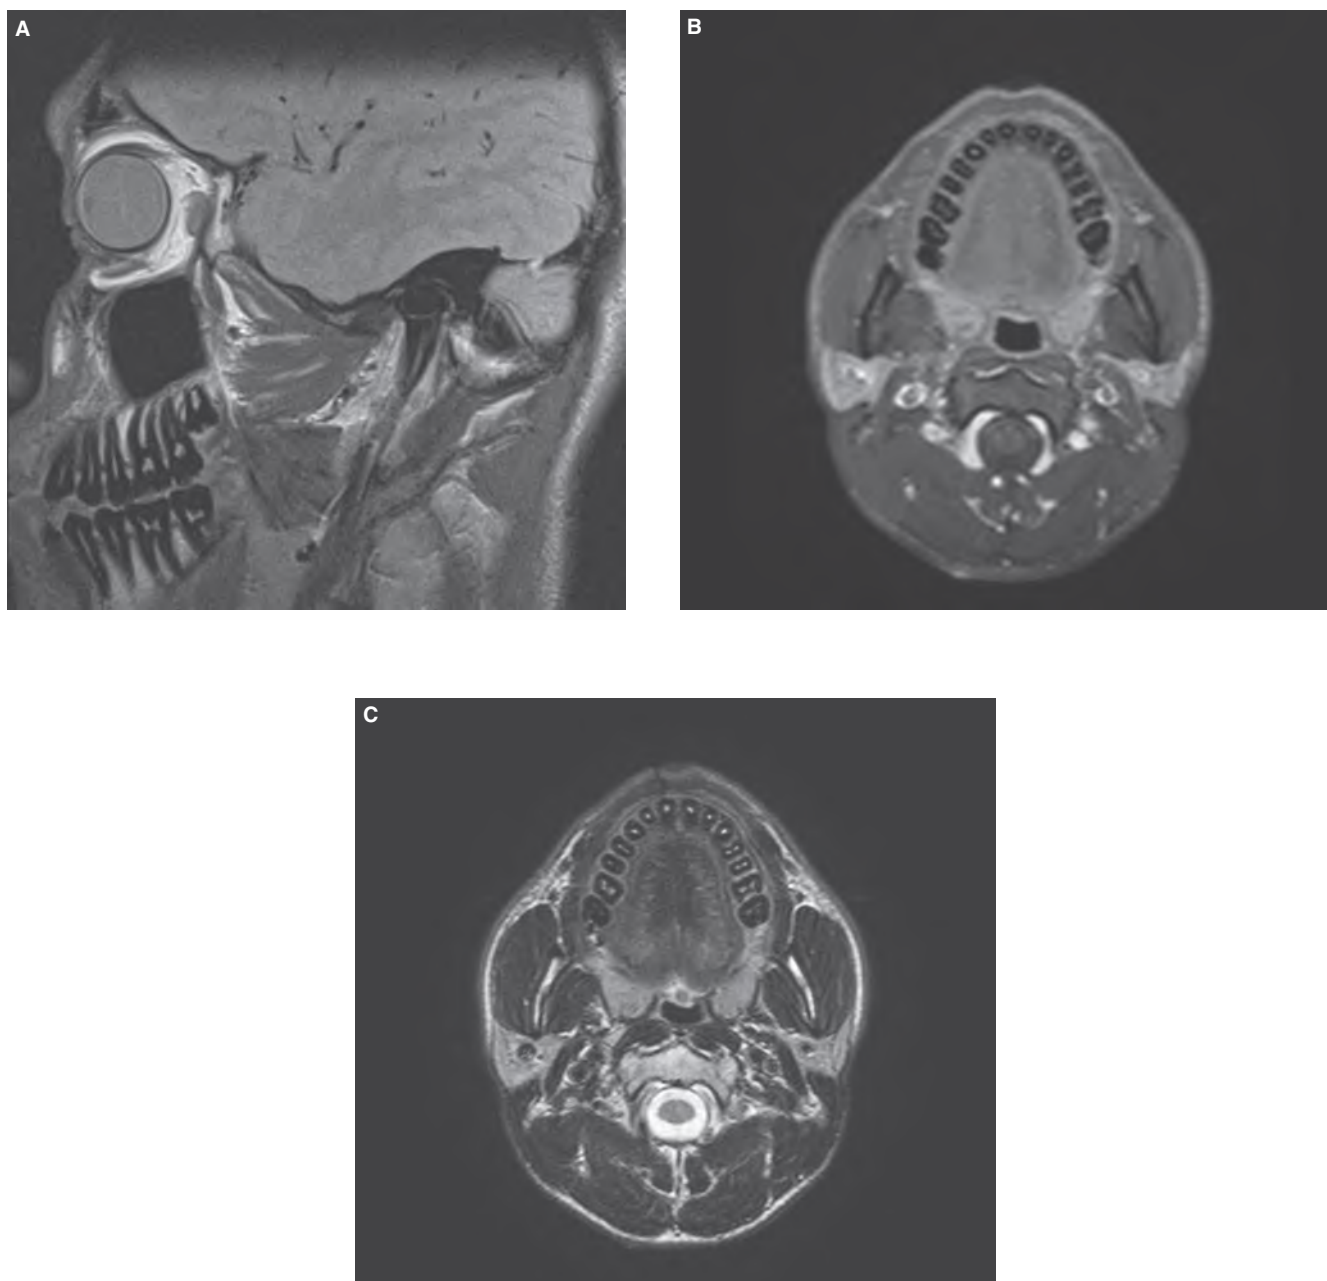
1 MRI scan of teeth and related tissues using head and neck coil with 3-T magnet. A. Sagittal MR imaging of orofacial area. Pulp tissues produce high MRI signal with brilliant image. B. T₁-weighted axial MRI scan. C. T₂-weighted axial MRI scan. (Courtesy of Dr. Burce Özgen Mocan, Ankara, Turkey.)
